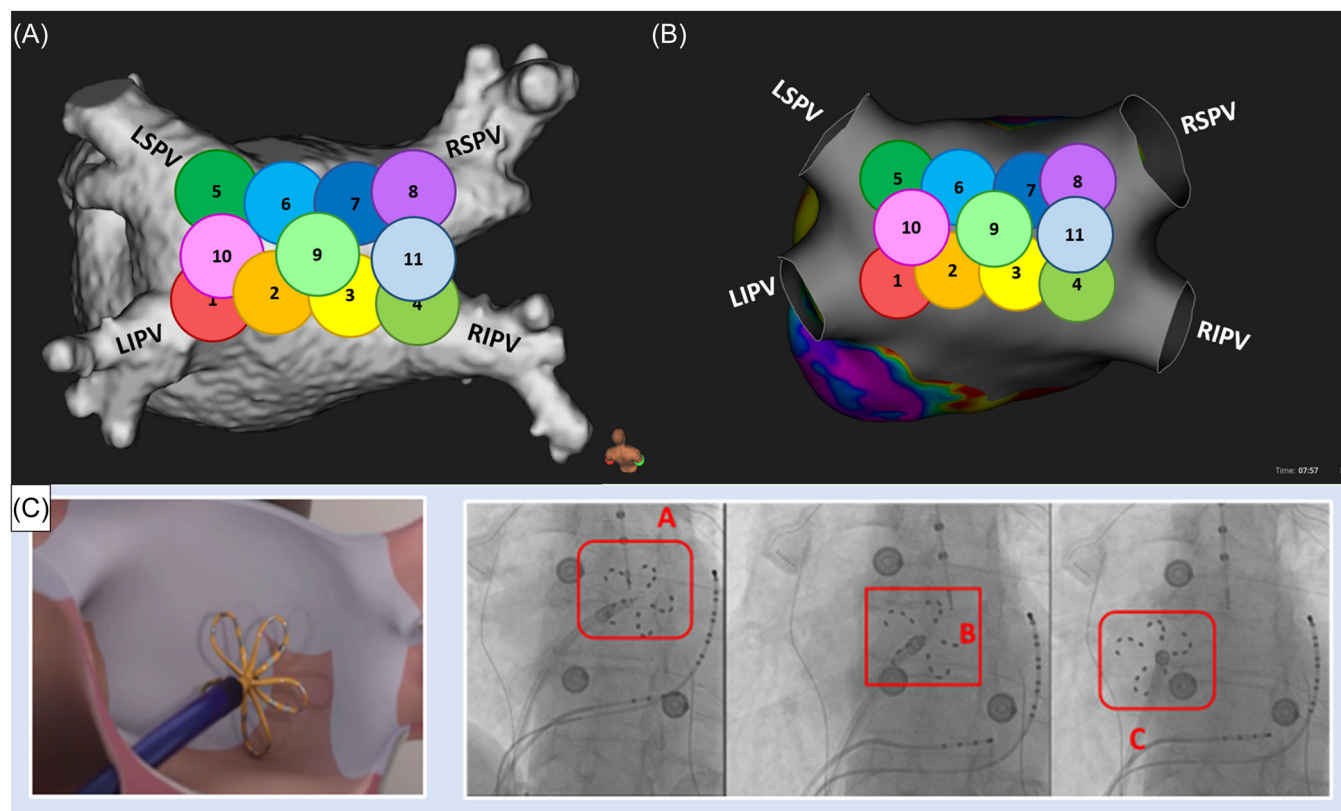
Once PVI was completed, LAPW isolation was performed at operator's discretion. To achieve LAPW isolation, PFA was applied to create continuous lesions adjacent to each other, connecting the floor (between the bottoms of the right and left inferior PVs, circles 1–4), the roof (between the tops of the right and left superior PVs, circles 5–8) and the inner wall (within the floor and the roof, circles 10 and 11) to complete entire PW isolation. Additional lesions were performed at carina sites, whenever required (circle 9). (Panel A): CT reconstruction of the left atrium anatomy; (Panel B): 3D-mapping reconstruction of the left atrium; (Panel C): Example of fluoroscopy visualization of LAPW ablation. LAPW, left atrial posterior wall; PFA, pulsed field ablation; PV, pulmonary veins; PW, posterior wall.
